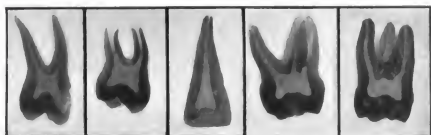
Radiographs showing large pulp chambers, such as found in young teeth.
